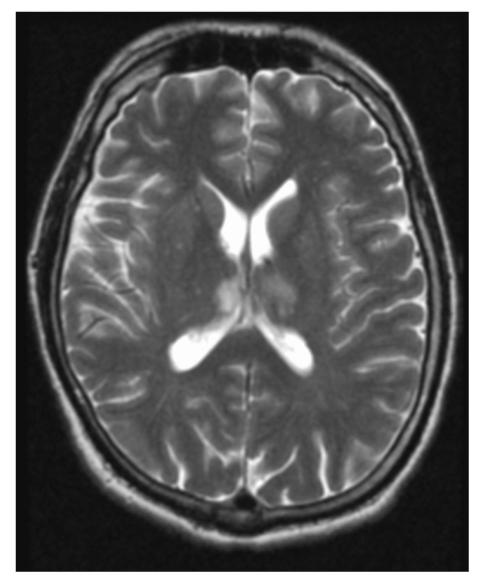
The T2-weighted spin echo axial brain image, obtained with TR= 2400 msec and TE= 90 msec, has bright image intensity for long-T2 tissues such as cerebrospinal fluid and dark intensity for short-T2 tissues such as white matter and fat.
